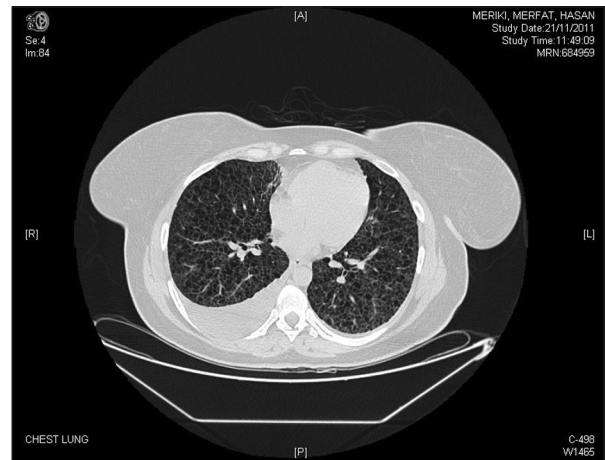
High resolution computed tomographic scan before lung transplantation
